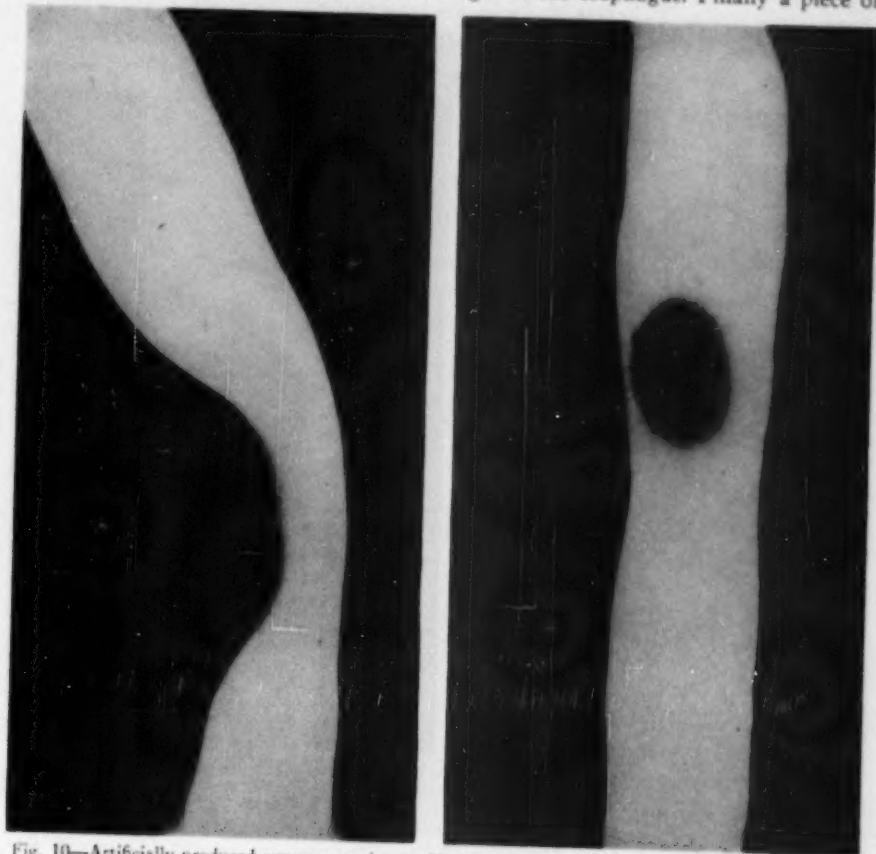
Artificially produced pressure on the outside of the esophagus. (Piece of cork pressed against the outside wall of a postmortem esophagus.) Note the gradual slope in the region of the pressure in profile and face on views in contradistinction to the sharp edge of the intramural lesion. (From Schatzki, R. and Hawes, L. E. *Am. J. Roentgenol.* 48:1-15, 1942.)
